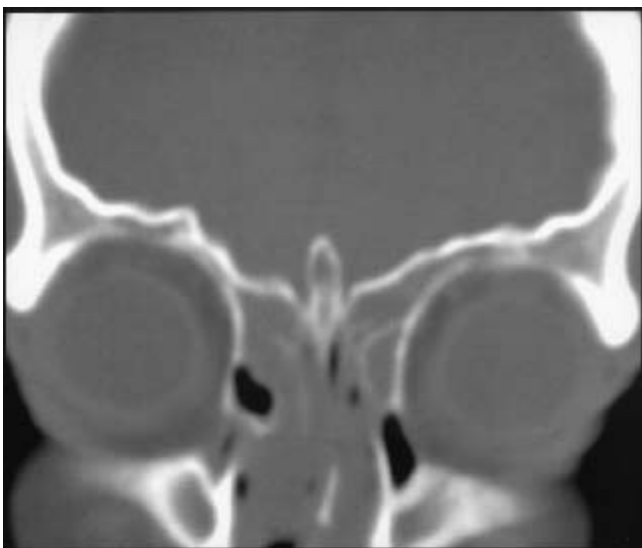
The preoperative CT-scan (a) shows an almost complete opacification of the ethmoid labyrinth and nasal cavities due to extensive polyposis. The ethmoid roof is intact. In the postoperative scan (b) we see a pneumocephalon and a bony lesion of the ethmoid roof (arrowhead).
